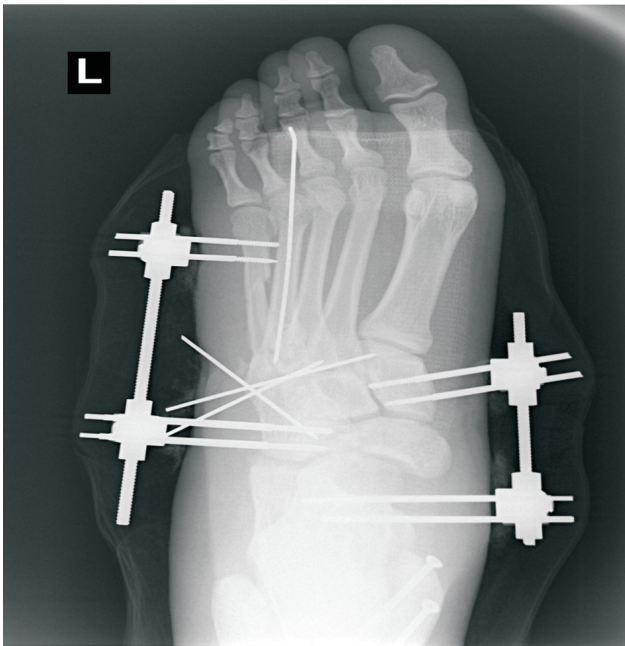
Radiographic view at 2 weeks postoperative showing callus formation and good alignment.
